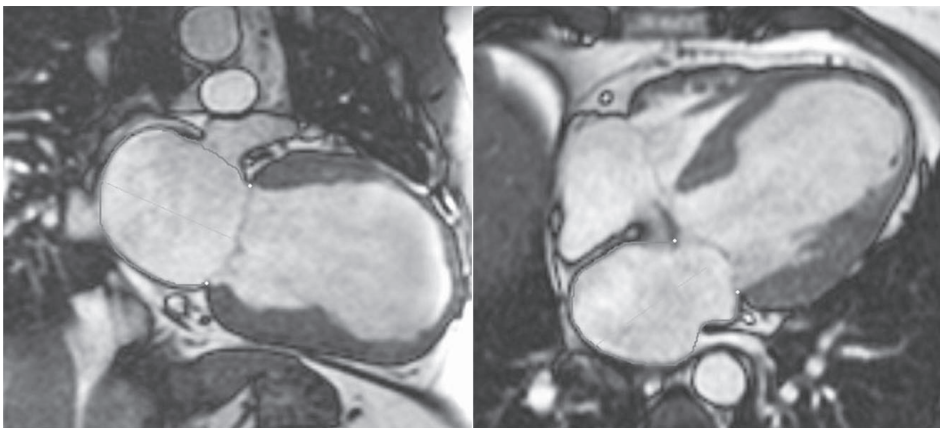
Assessment of LA volumes with MRI. The 2-chamber (left panel) and the 4-chamber (right panel) views are used to delineate the endocardial border of the LA, as well as the maximal diameter.
